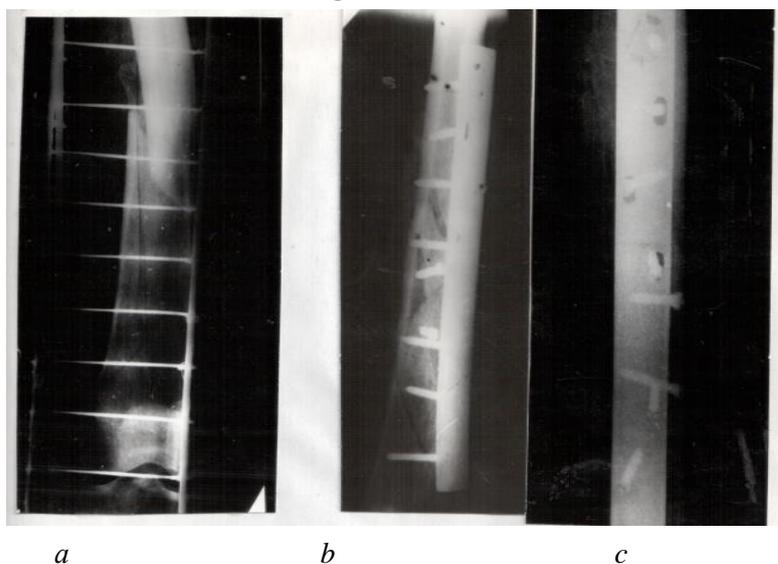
Radiography images of patient B. GA show fracture of the left femur (a) in the midleg with displacement. Fragments are matched and fixed by plate with screws (b) - 4 days after osteosynthesis. Follow-up period -2 months after operation (c). Follow-up period - 4 months. (d). Femur after removal of fixator (e).
